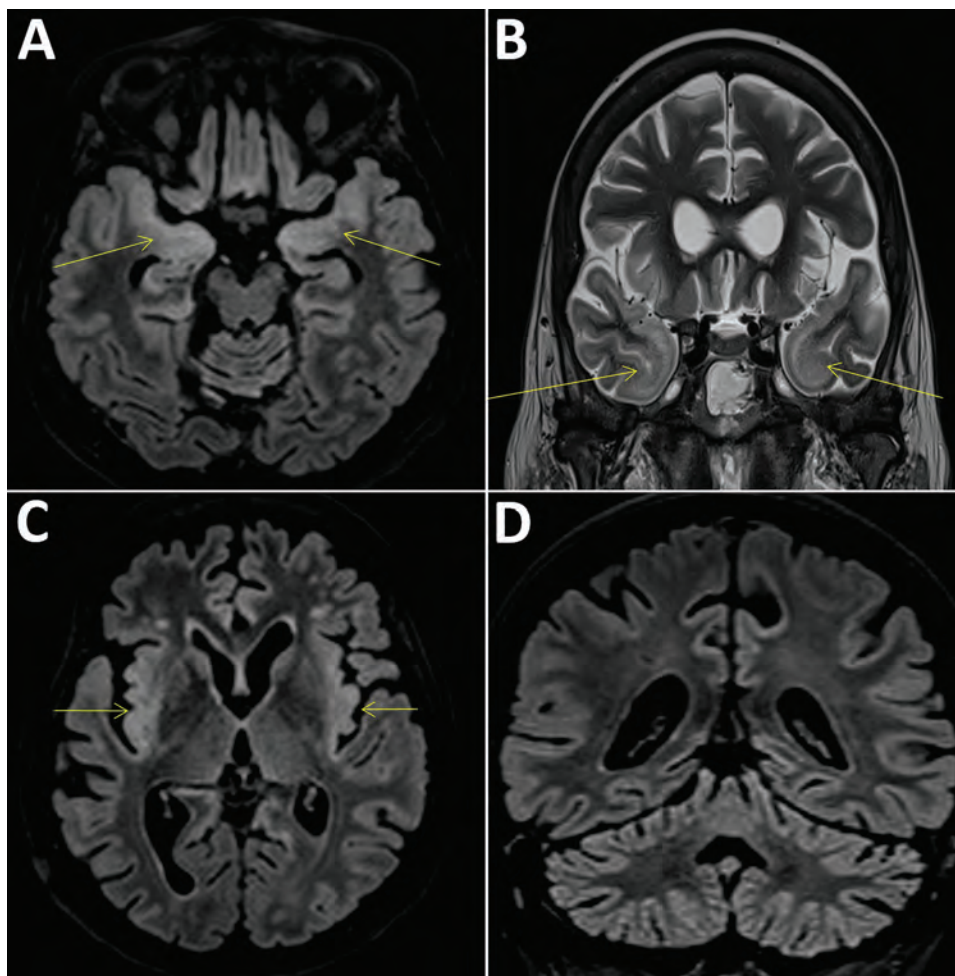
Cerebral magnetic resonance imaging scans compatible with the diagnosis of encephalitis in a 58-year-old woman, France. Fluid-attenuated inversion recovery (FLAIR) and T2 hypersignals in limbic system structures, including both amygdalae (A, arrows), temporal poles (B, arrows), and insular cortex (C), associated with FLAIR hyperintensities of the cerebellar cortex (D).
